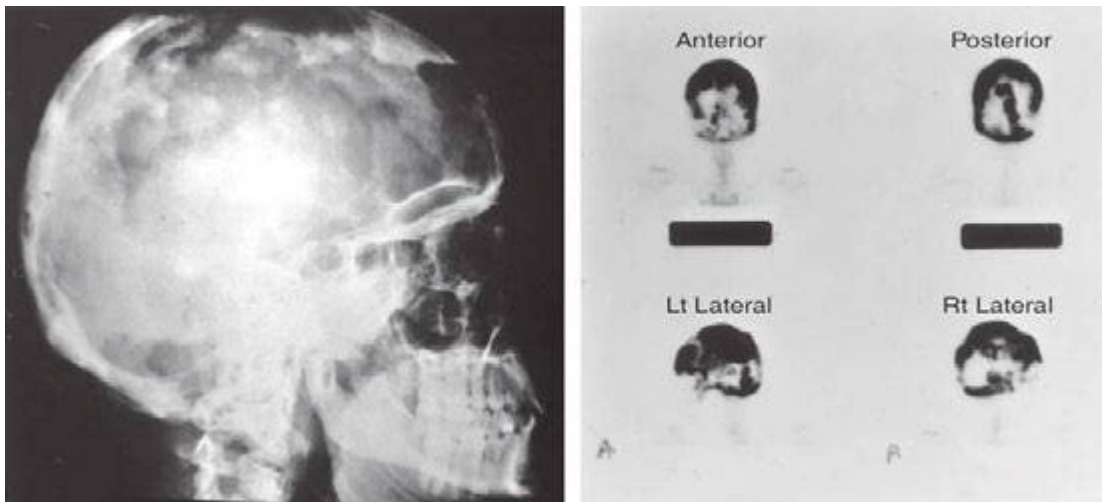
2 A 48-year-old woman with Paget's disease of the skull. Left. Lateral radiograph showing areas of both bone resorption and sclerosis. Right. ^{99m}Tc HDP bone scan with anterior, posterior, and lateral views of the skull showing diffuse isotope uptake by the frontal, parietal, occipital, and petrous bones.
